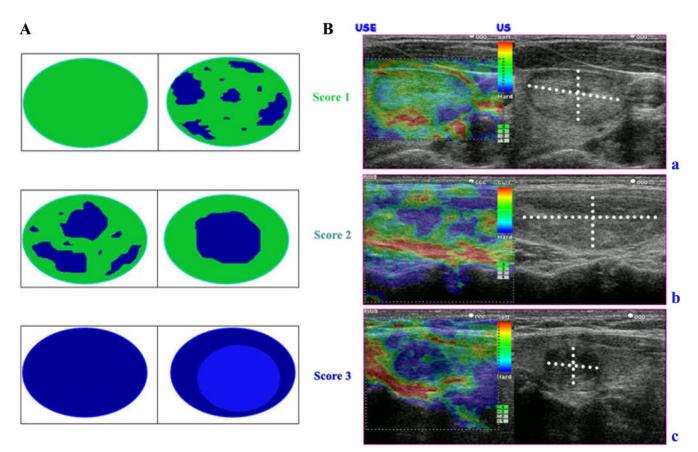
Elasticity score. A, Score 1, Elasticity in the whole or in a large part of the nodule; score 2, elasticity only at the peripheral part of the nodule; score 3, no elasticity in the nodule and in the posterior shadowing. B, Ultrasound elastography (USE) and conventional US (US) of three thyroid nodules with an elasticity score 1 (a), score 2 (b); and score 3 (c).
